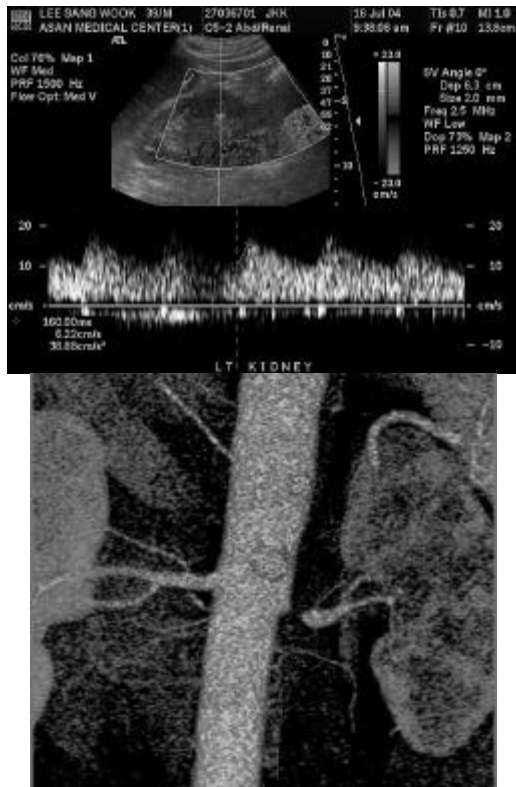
The figure on the left shows tardus-parvus wave-forms and delayed-dempened upstroke on Doppler US and severe stenosis at osteum of Lt.renal artery(more than 90% diameter stenosis) on 3D CT(bottom).
